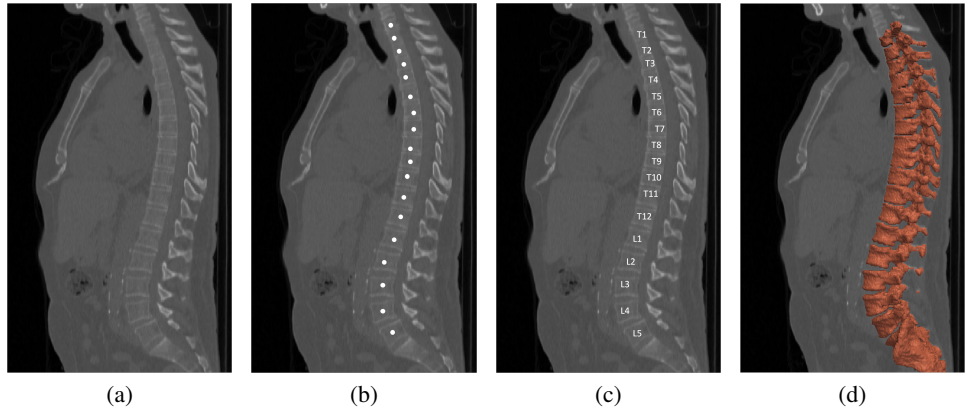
a) A slice of a 3D CT image which includes thoracic (T1-T12) and lumbar (L1-L5) vertebrae. b) Detection of the vertebrae on the CT images. c) Identification (labeling) of the detected vertebra. d) segmentation of the identified vertebra.
